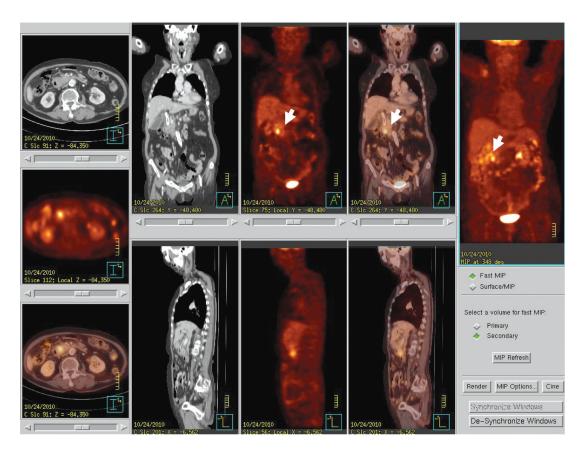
PET/CT images show 1.3 cm. hypermetabolic mass at pancreatic head (arrow), without regional node and distant metastasis (stage $T_1N_0M_0$)
